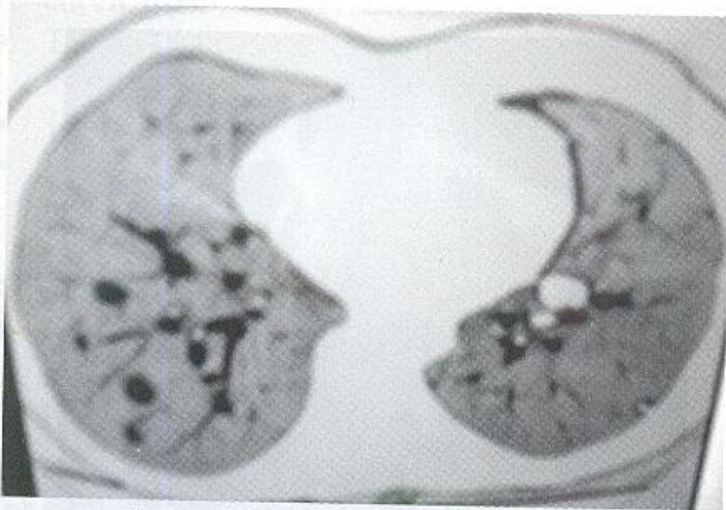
HRCT chest. Invert film.
